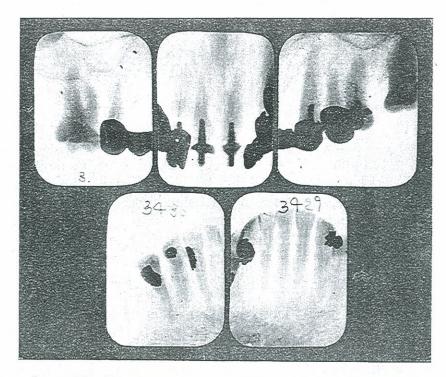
ROENTGENOGRAPHIC APPEARANCE OF DENTAL INFECTIONS OF A PATIENT SUFFERING FROM CHRONIC CHOLECYSTITIS. FOLLOWING EXTRACTIONS, PATIENT PASSED FIFTY-TWO GALL-STONES.
